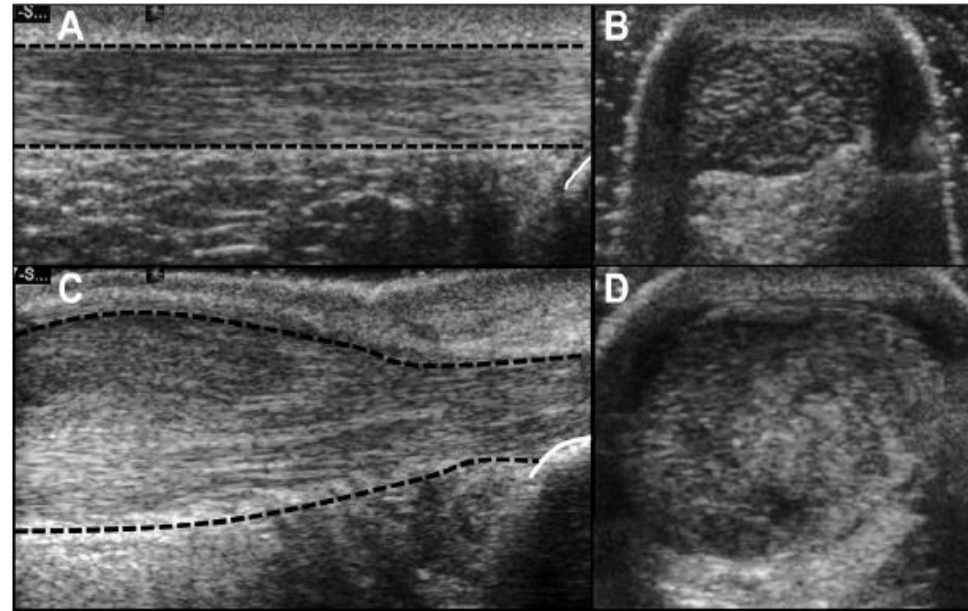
Ultrasound of a healthy Achilles tendon. (A) Longitudinal and (B) transverse ultrasound images of the mid Achilles tendon. The normal tendon texture appears homogeneous, with parallel echogenic lines reflecting the internal fibrillar structure of the tendon. The dashed blue lines represent the superficial and deep borders of the tendon.
